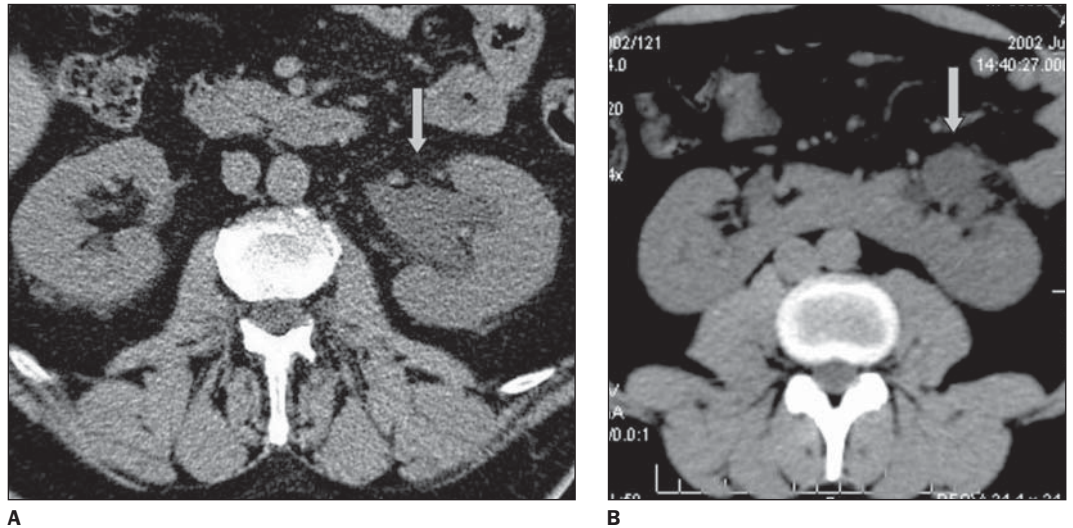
Calyceal system dilatation. Non-enhanced CT axial slices. A: A mild dilatation (arrow) in a patient presenting calculus in the left ureterovesical joint (not evidenced in this image). B: A patient presenting horseshoe kidney and left ureterovesical joint 3 mm calculus causing mild ureteral dilatation (arrow).
